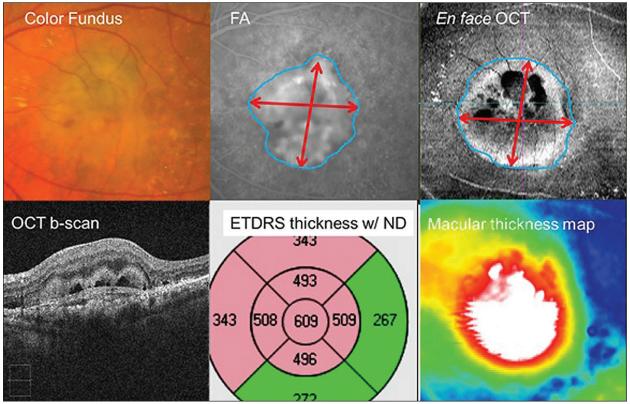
When selecting patients for x-ray SRT, measure the lesion greatest linear dimension using FA (top middle) or en face OCT images (top right). When using OCT B-scans, cycle through consecutive cross-sectional images to find the image depicting the longest lesion length (bottom left). The significance and amount of macular fluid can be quantified using ETDRS sector average thickness with normative data color coding (bottom middle) or macular thickness maps (bottom right).
